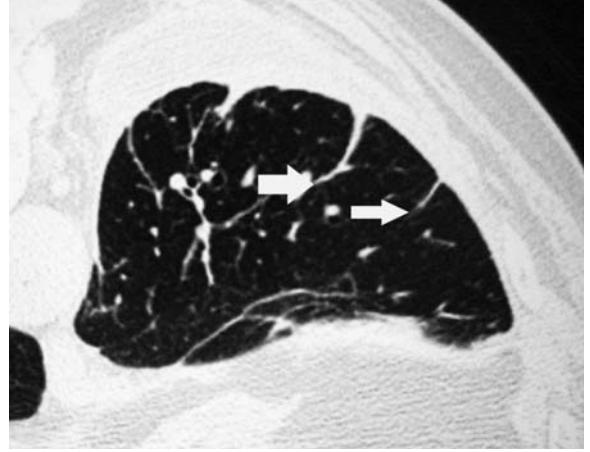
Prone thin-section computed tomography of an asbestos-exposed individual showing multiple parenchymal bands (*arrows*) arising from an area of pleural thickening
